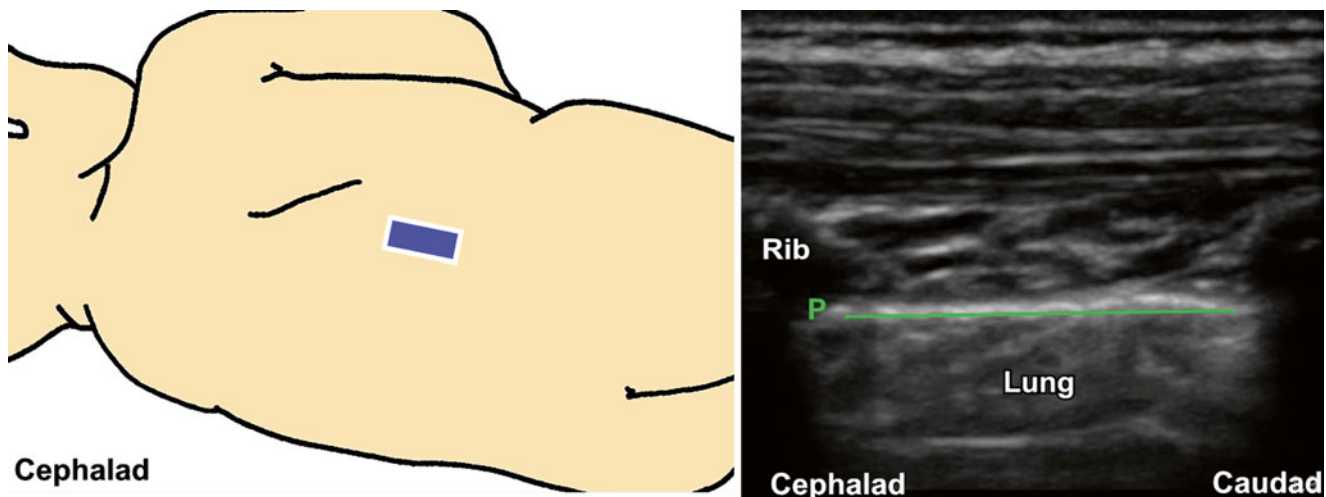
Ultrasound image of the intercostal space. *P* pleura
